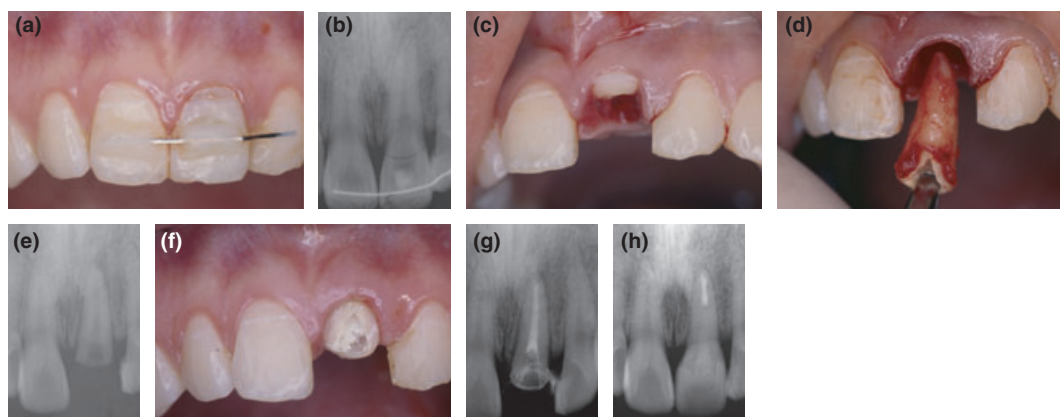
(a) Pretreatment facial view of resin–wire splinted tooth #21 at first visit. (b) Pretreatment periapical radiograph of crown-root fractured tooth #21 at first visit. (c) Clinical view after removal of fractured coronal fragment tooth #21 at first visit. (d) Clinical view after extraction of apical segment of tooth #21 at first visit. (e) Periapical radiograph of replanted apical segment of tooth #21 in a rotated and slightly extruded position at first visit. (f) Clinical view after suture removal 1 week after replantation. (g) Periapical radiograph of root-filled replanted tooth #21 1 week after replantation. (h) Periapical radiograph of replanted tooth #21 at 24-month follow up showing restoration and complete apical healing.
